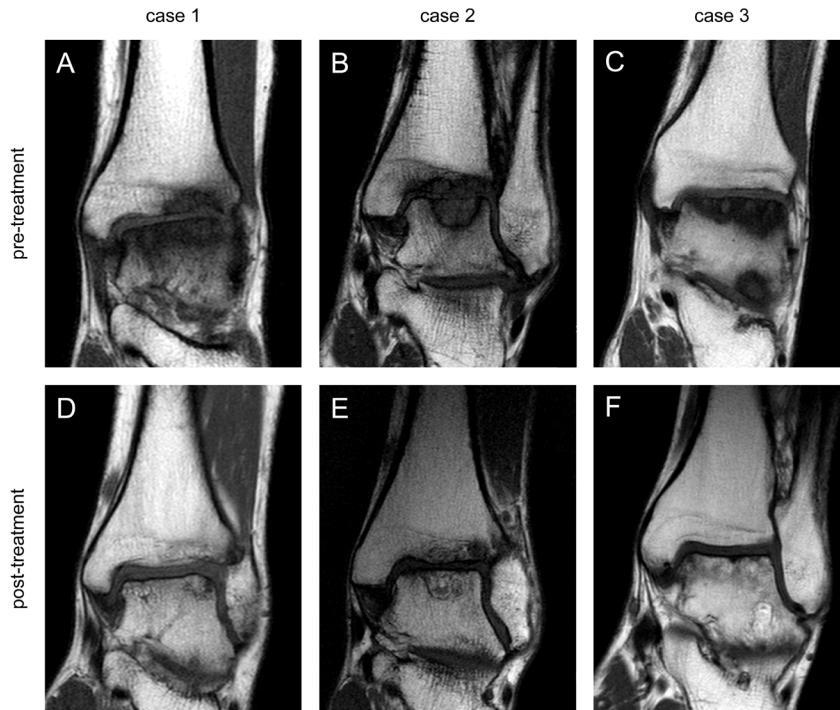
Structural improvement after ankle distraction on MRI
